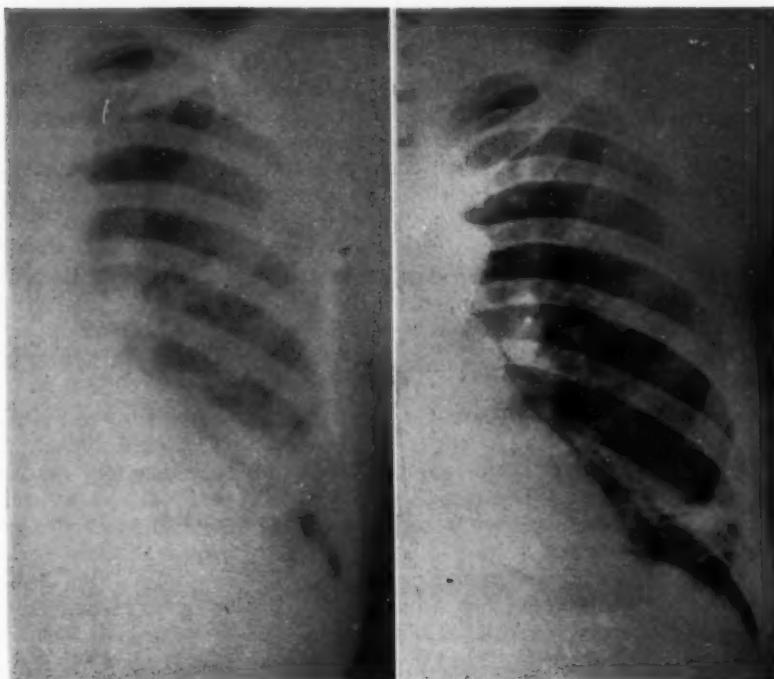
Chest roentgenograms of a 28 year old colored man with sickle cell anemia who entered the hospital with fever and pleuritic left chest pain. At the left is roentgenogram on admission showing wedge-shaped infiltrate at the left base. On the right is roentgenogram two weeks after admission showing linear healing characteristic of pulmonary infarction.
